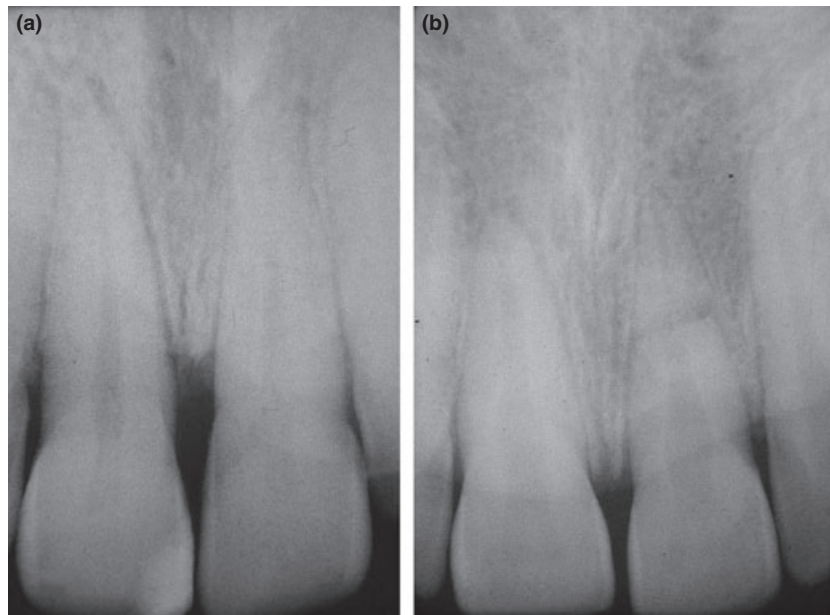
In an orthoradial intraoral radiograph, an enlargement of the periodontium of teeth 1.1 is shown, no fracture line is shown in teeth 2.1 (a). Moving the cone beam apically, a clear fracture line is shown in teeth 2.1 (b).
